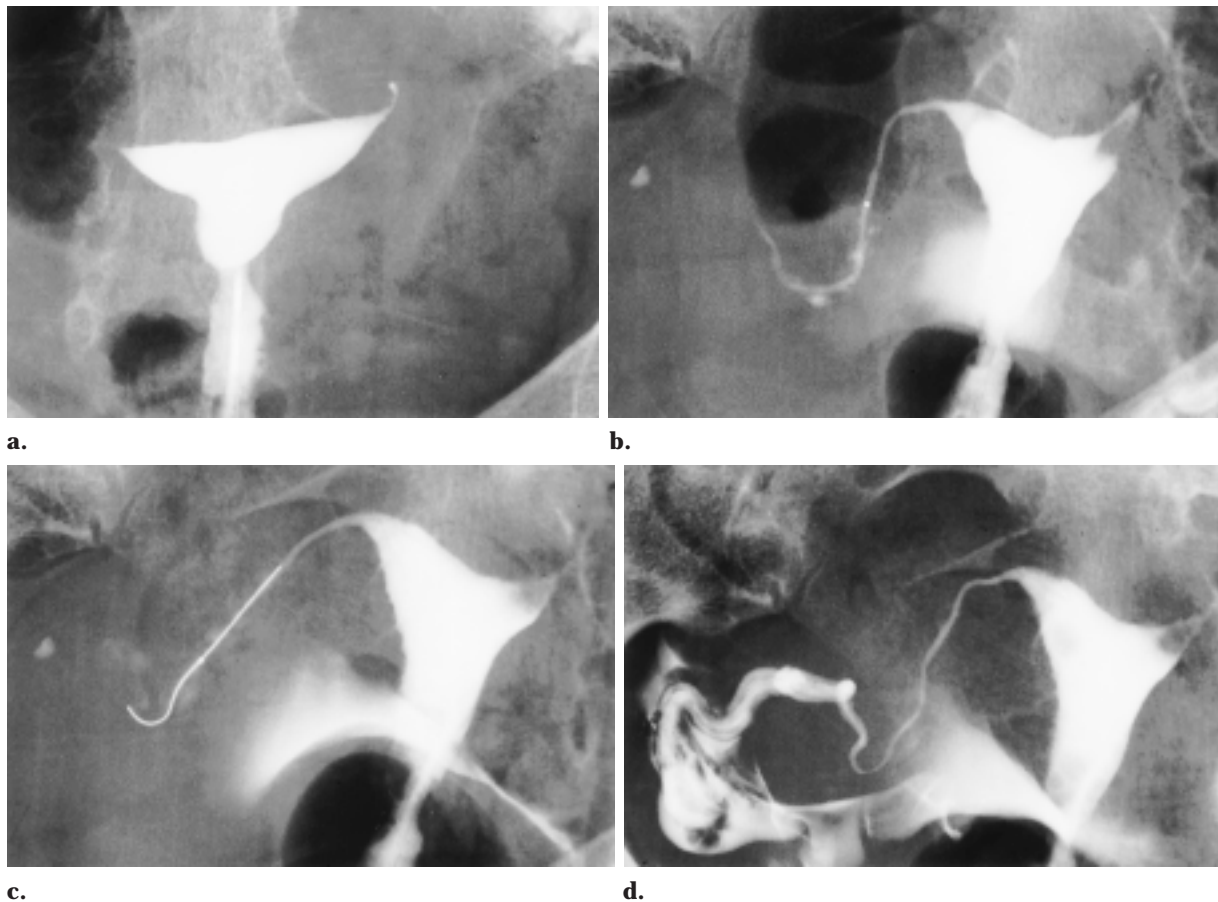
Successful recanalization of a more distal tubal obstruction with use of a softer tapered system. (a) Hysterosalpingogram demonstrates bilateral proximal tubal obstruction. (b) Radiograph, obtained after successful recanalization of the proximal obstruction of the right tube, reveals a second obstruction in the isthmus portion of the same tube. (c) Radiograph shows a 0.014-inch floppy guide wire supported by a 2.7-F tapered catheter (with a radiopaque bead at the tip) that was used to pass the second obstruction. (d) Subsequent radiograph obtained after a repeat ostial injection of contrast material now reveals a patent normal tube.
